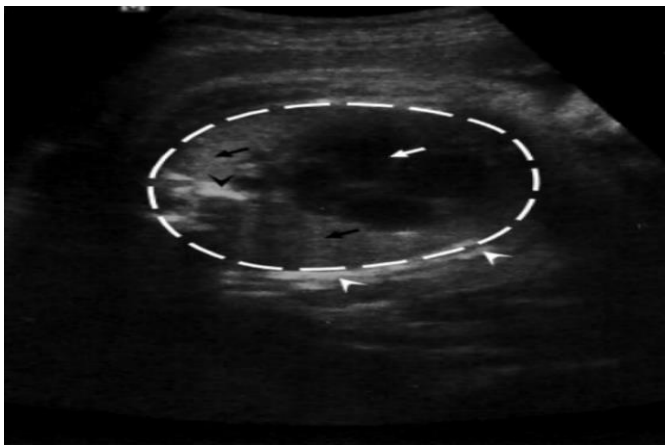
Sonogram of the foetal chest on a transverse view at the level of the 4-chamber view of the foetal heart. Foetal chest circumference (broken white line). Foetal heart (white arrow), foetal lungs (black arrow), foetal
